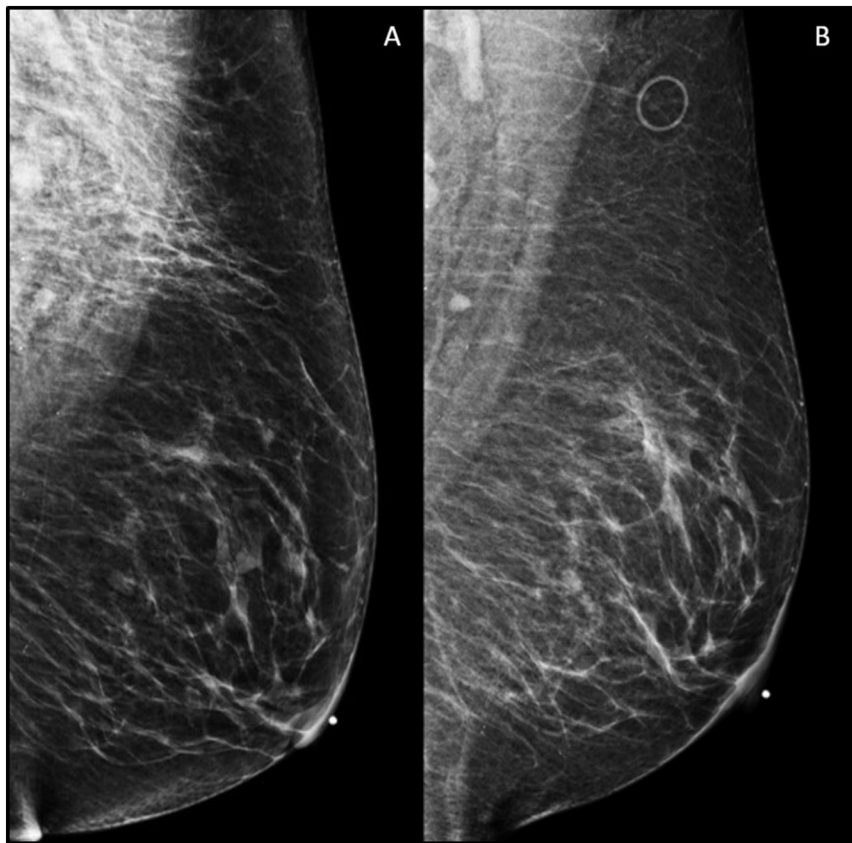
A 60-year-old woman presented for screening mammogram and breast ultrasound two days following the 2nd booster dose of the Moderna COVID-19 vaccination in the left deltoid. (A) Mediolateral oblique view of the left breast obtained during screening mammogram demonstrated a new global asymmetry with trabecular thickening in the axillary region. (B) Mediolateral oblique view of the left breast thirteen days later at the time of diagnostic imaging demonstrated complete resolution of the asymmetry.
